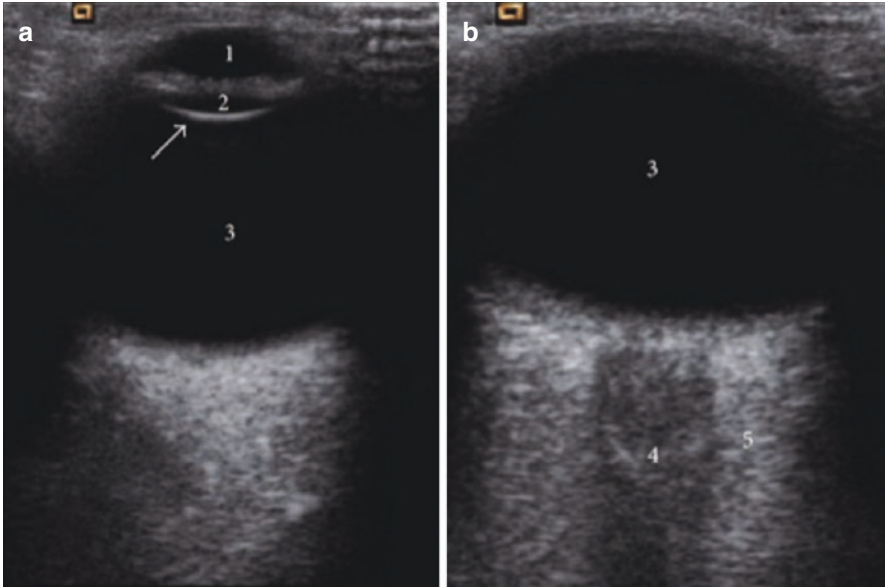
OCCS: Axial (Transverse) B-Mode ultrasound image that shows normal anatomy of ocular structures; (a) (1) Anterior chamber, (2) Lens and (3) Vitreous body; (b) (3) Vitreous body (bulbus), (4) Optic nerve sheath complex and (5) Retrobulbar fat. (Courtesy: Jiménez Aragón et al. [32])
